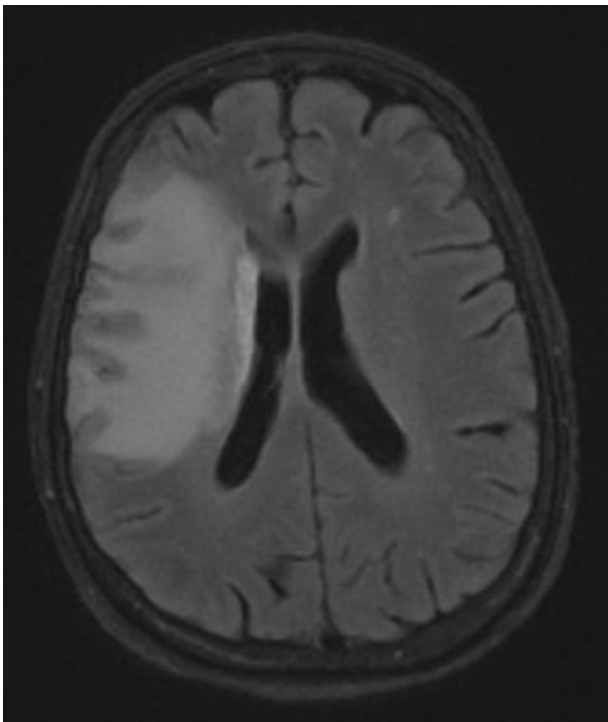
MRI brain during hospitalization for seizure demonstrating interval progression of vasogenic edema and new enhancing nodules suggestive of granulomatous inflammation.
